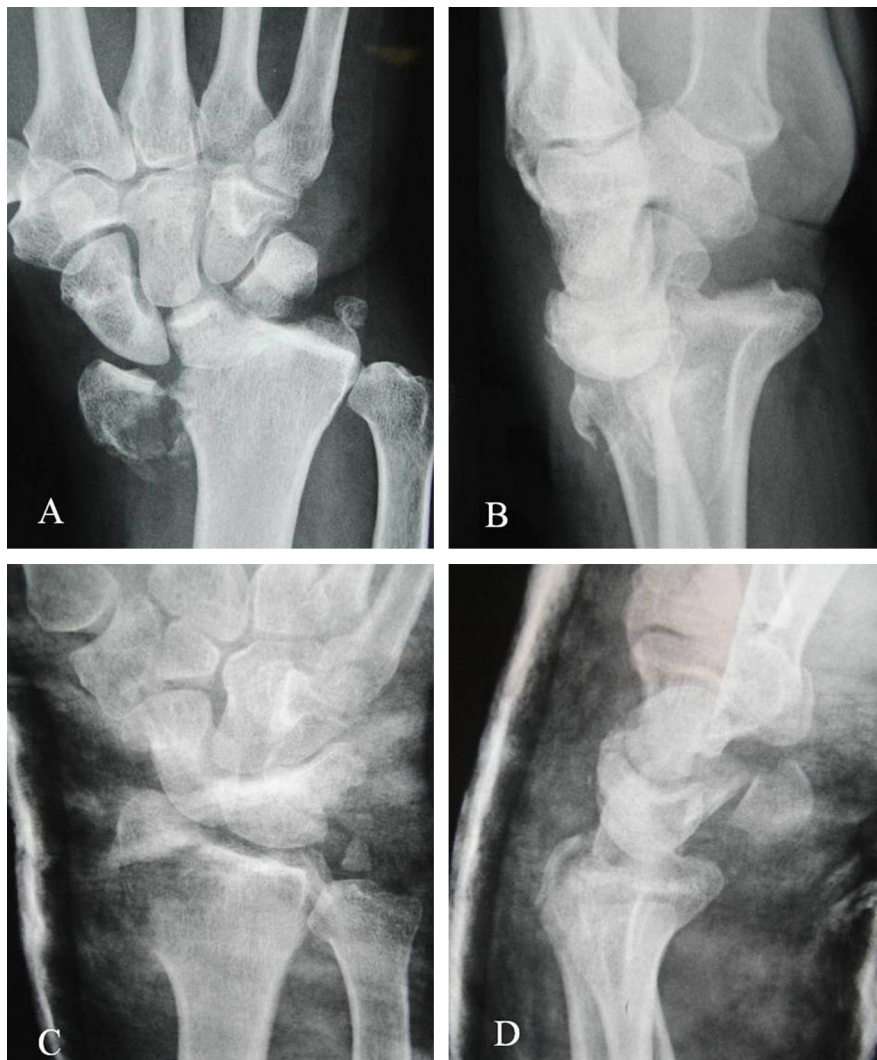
The anterior-posterior (A) and the lateral (B) x-rays of the right wrist taken after the trauma revealed a displaced radial styloid fracture, dorsal dislocation of the carpus and ulnar styloid fracture. Closed reduction and cast immobilization for one month was performed as the emergency treatment (C, D).
